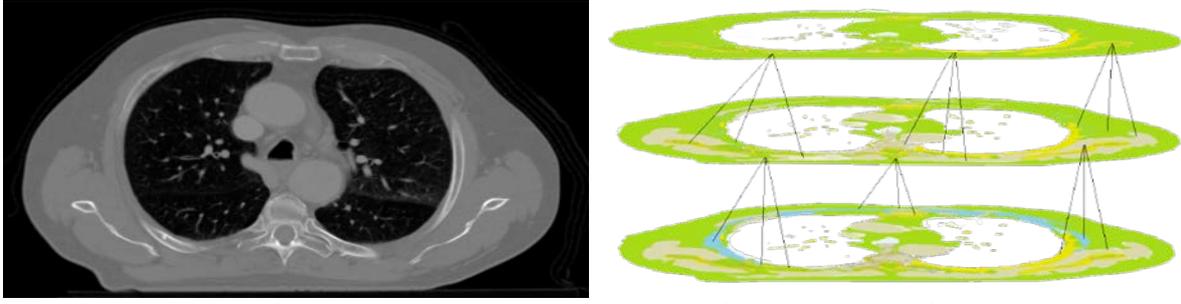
The raw image of a computed tomographic image of lung cancer before processing into selective search (left). The selective search alike pyramid structure layer-wise processing for classification of cancer nodule (right).
